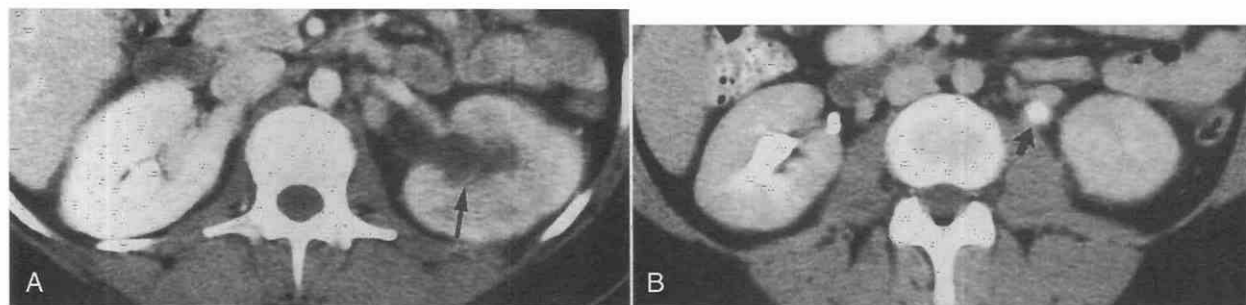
CT Scans of pyonephrosis and severe urosepsis due to an obstructing left ureteric urate calculus not visible on plain films. A, There is decreased enhancement of the left renal parenchyma, and the left renal pelvis is dilated with delayed contrast excretion (arrow). B, An obstructing calculus (arrow) is present in the proximal ureter. Differentiation between simple hydronephrosis and pyonephrosis could not be made by CT. However, the diagnosis of pyonephrosis was suggested by clinical findings. The patient showed rapid response to percutaneous nephrostomy.
